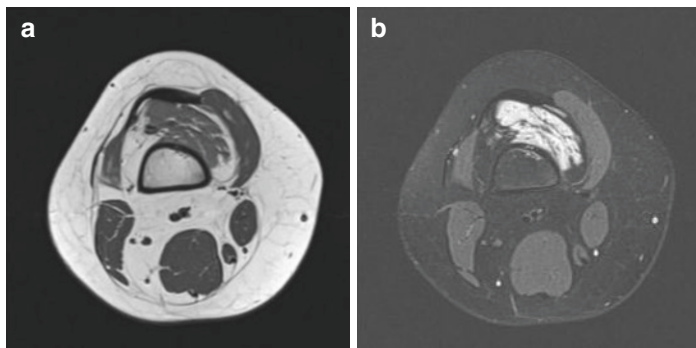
MRI of a thigh venous malformation in a 17-year-old teenager. (a) Axial T1-weighted image shows a poorly defined, partially infiltrating hypointense mass in the anterior to the femur bone. (b) Axial T2-weighted image shows the well-defined exophytic hyperintense fluid intensity mass in the left chest wall
